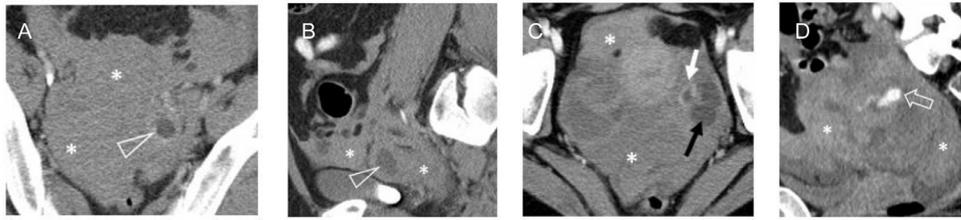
Although it can be difficult to diagnose on CT, familiarity with CT signs of ectopic pregnancy is important. (A) and (B) axial and sagittal CT images show an extrauterine gestational sac with mild peripheral enhancement (open arrowhead) and large volume hemoperitoneum (asterisk) in a patient with ruptured ectopic pregnancy. (C) and (D) axial and sagittal CT image show active extravasation (open arrow) from the right adnexa and large volume hemoperitoneum (asterisk) in a patient with ruptured ectopic pregnancy. Note the contralateral left sided hydrosalpinx (black arrow) and a corpus luteal cyst (arrow).
